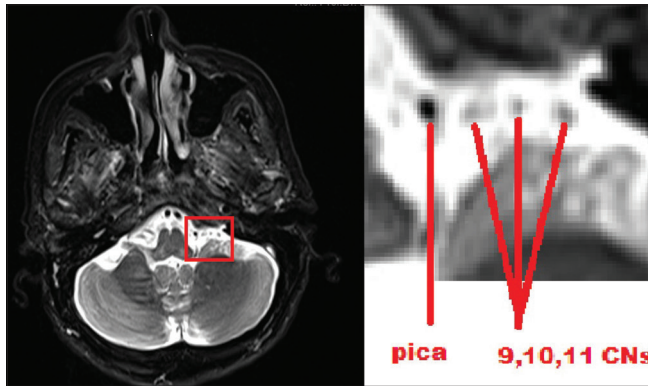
Preoperative T2 axial magnetic resonance imaging image shows posterior inferior cerebellar artery compression on the 9<sup>th</sup> and 10<sup>th</sup> cranial nerves
